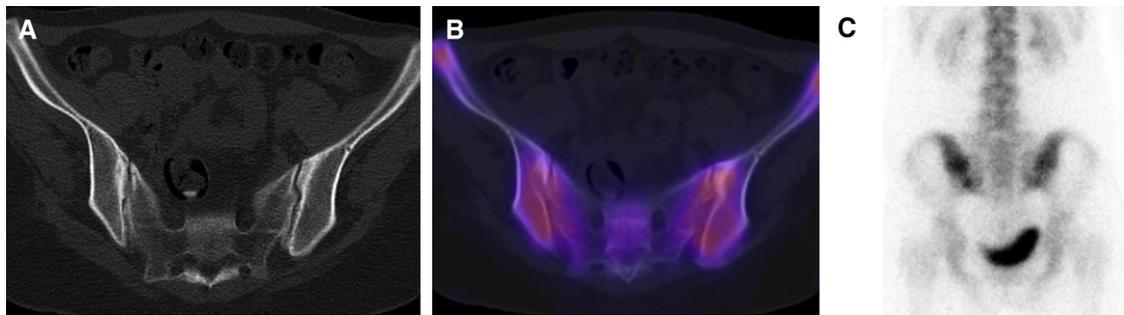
Ankylosing spondylitis with bilateral symmetric sacroiliitis on technetium 99m single-photon emission computed tomography (SPECT) computed tomography (CT) bone scan. (A) Axial CT image shows bilateral subchondral erosions and sclerosis. (B) Fused axial SPECT-CT and (C) posterior planar bone scan image demonstrates increased radiotracer uptake around both sacroiliac joints consistent with sacroiliitis. This figure is available in colour online at <http://carjonline.org/>.
